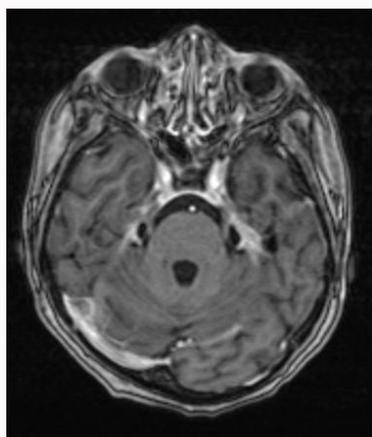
T1 weighted MRI showing hyperintense at the right cerebro-occipital area suggestive of vasculitis.
